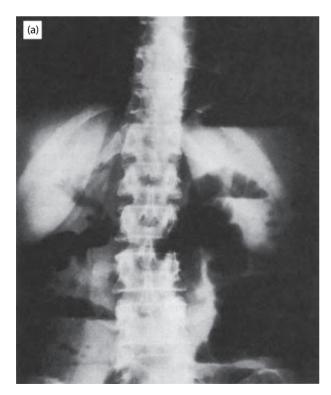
(a) Plain radiograph of the abdomen – gas outlines the common bile duct. The patient presented with cholangitis and gallstone ileus. A spontaneous cholecystoduodenal fistula was found at operation. (b) Gas outlining the right hepatic duct. The patient had an empyema of the gallbladder and a cholecystocolic fistula due to a carcinoma of the hepatic flexure.
